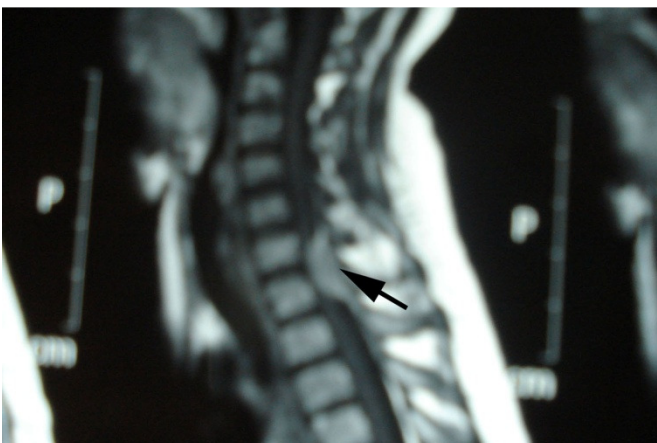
Sagittal T2-weighted magnetic resonance image showing intradural, extramedullary tumor at C7-D1 level (arrow)
